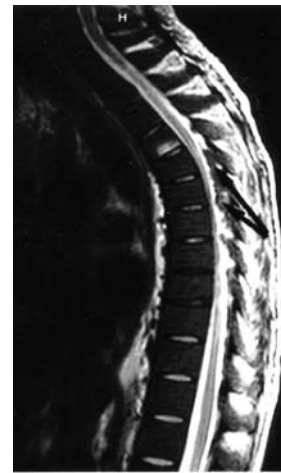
Sagittal MRI of thoracic spine 5 months after irradiation. Note minimal reduction of intraspinal EMH tissue. Arrows indicate the spinal mass. EMH - extramedullary hematopoiesis.
